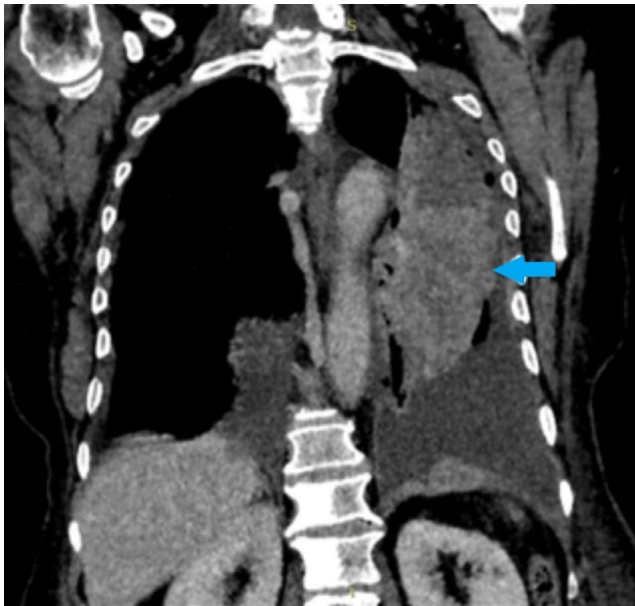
Coronal chest CT shows a poorly margined enhancing mass (blue arrow) in the left upper lobe abutting to the left pericardium with metastatic pericardial effusion and bilateral pleural effusion. Also showing multiple osteoblastic vertebral metastasis
